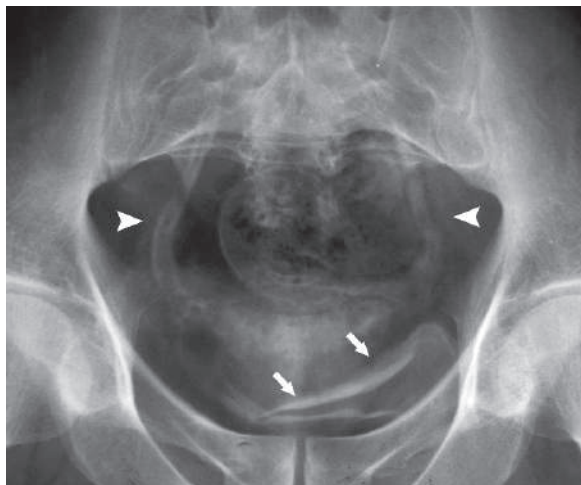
Plain radiograph of the pelvis shows complete bilateral calcification of the ureters (*arrowheads*) and the bladder (*arrows*) in a patient with bilharziasis
